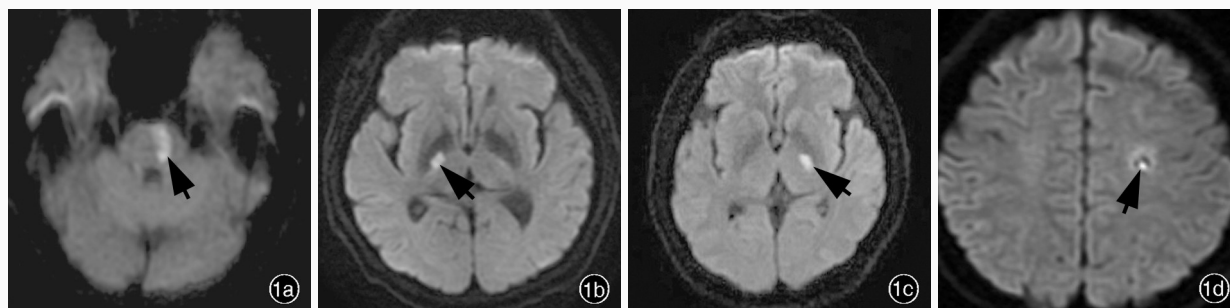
头部 MRI 检查所见 1a 例 6, 男性, 67 岁, 临床诊断为缺血性卒中。横断面 DWI 显示, 脑桥偏左新发梗死灶(箭头所示) 1b 例 3, 男性, 46 岁, 临床诊断为缺血性卒中。横断面 DWI 显示, 右侧内囊后肢新发梗死灶(箭头所示) 1c 例 7, 女性, 75 岁, 临床诊断为缺血性卒中。横断面 DWI 显示, 左侧丘脑新发梗死灶(箭头所示) 1d 例 4, 女性, 34 岁, 临床诊断为缺血性卒中。横断面 DWI 显示, 左侧半卵圆中心新发梗死灶(箭头所示) 1e 例 9, 男性, 61 岁, 临床诊断为缺血性卒中。横断面 DWI 显示, 双侧枕叶未见梗死灶
